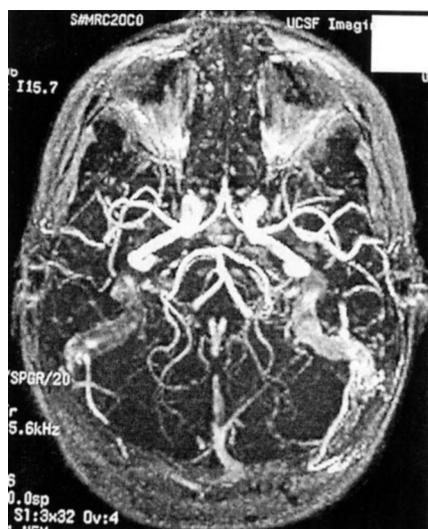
Magnetic resonance angiography combined with magnetic resonance imaging of transverse or sigmoid sinus dural arteriovenous fistula (TS DAVF).
